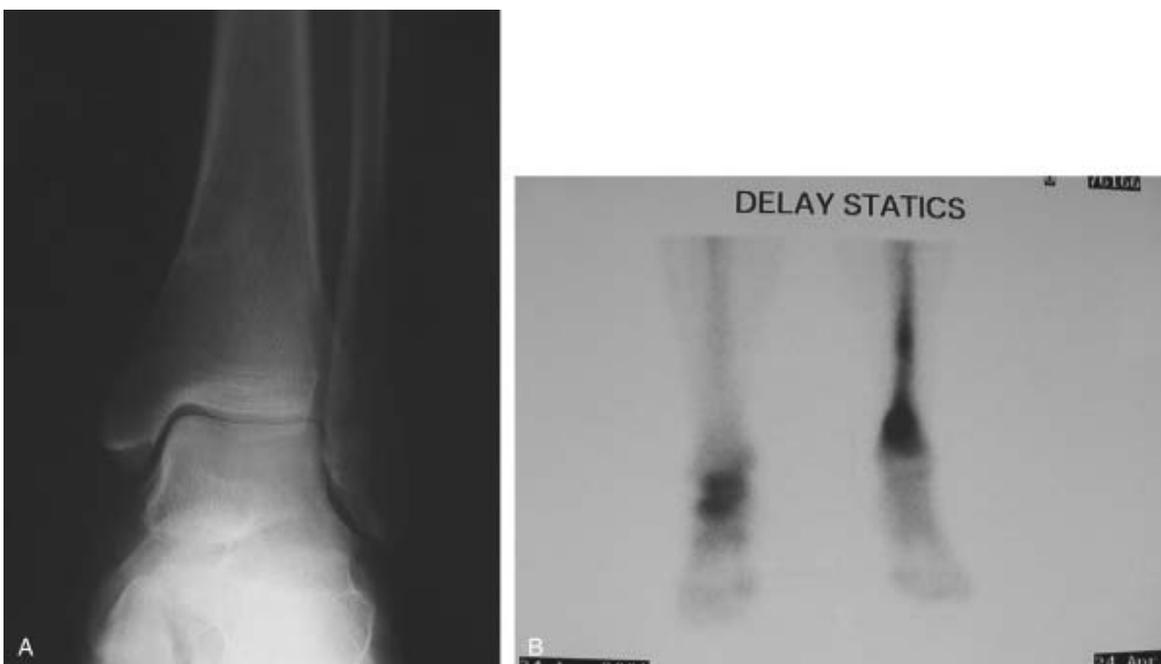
1 A, Minimal radiographic findings with no cortical involvement. B, Diagnosis of tibial stress fracture confirmed by technetium-99m bone scan. (Courtesy of James W. Brodsky, MD.)
